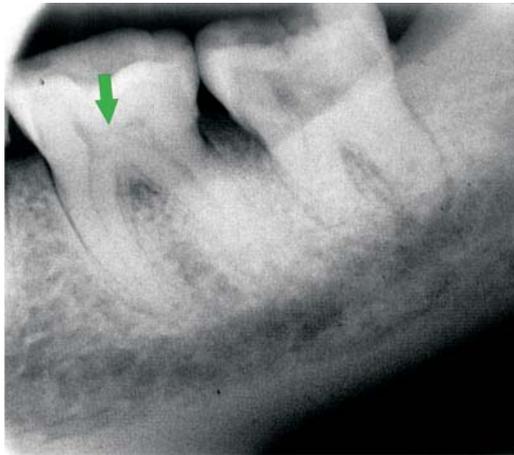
Retro-alveolar radiography of a 58-years old patient in which it is evidenced a well-grown denticle which occupies almost half the pulp chamber of the 4.7 molar; it is also noticed a diffuse demineralization area between the 4.7 and 4.8 molars
